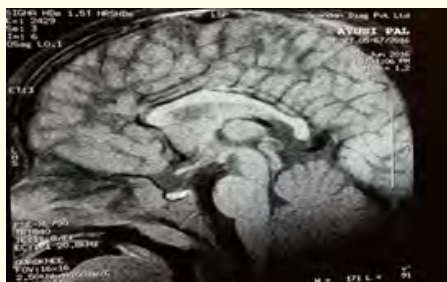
Magnetic resonance imaging MRI of Hypothalamo pituitary region reveals no obvious abnormality.
